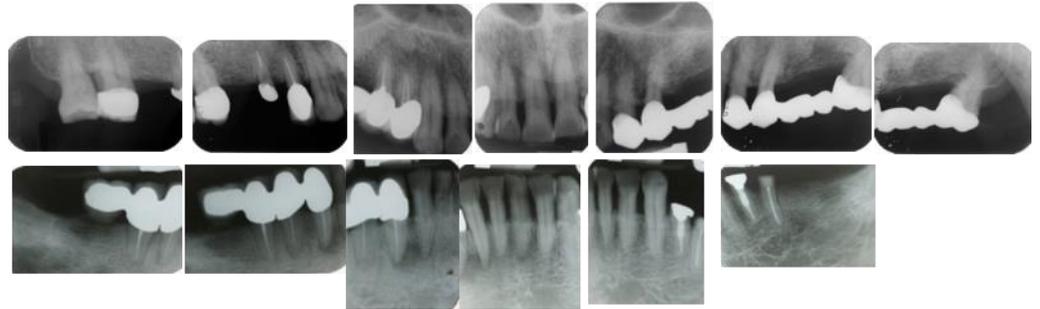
Showed that the dental periapical radiographs of full mouth at the baseline. (2002/4/9).
